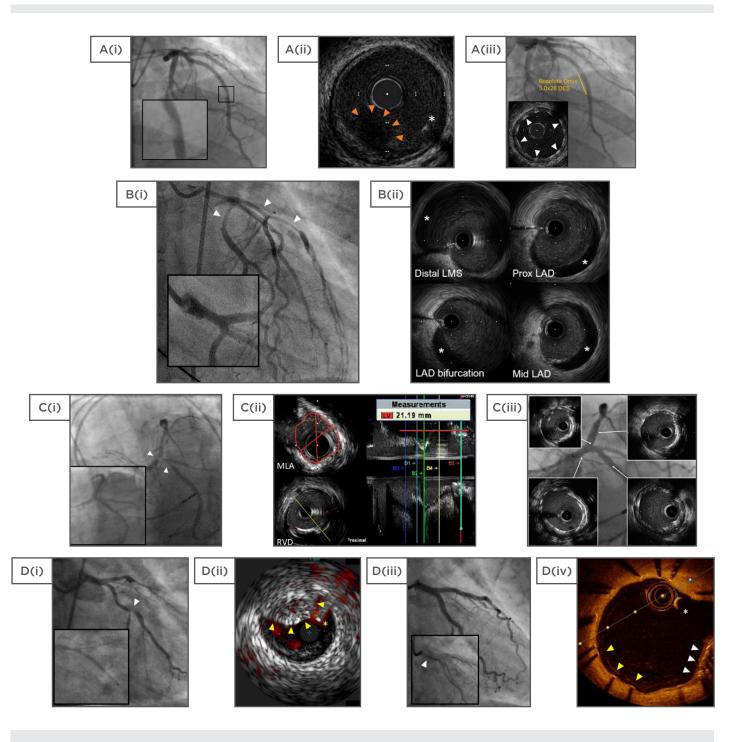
Selected cases using intravascular ultrasound and optical coherence tomography.
